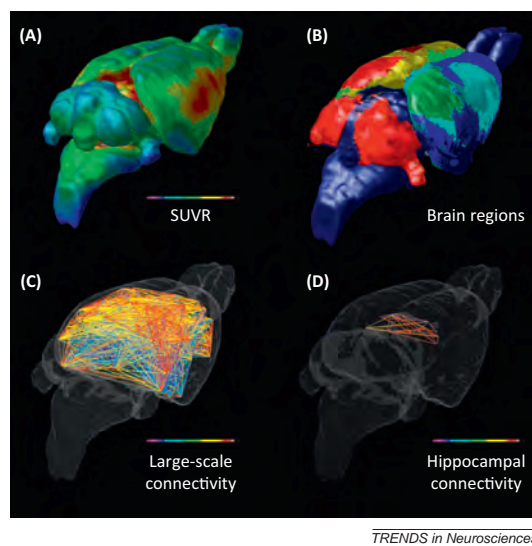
Brain metabolic network inferred from microPET [ $^{18}\text{F}$ ]FDG imaging.
